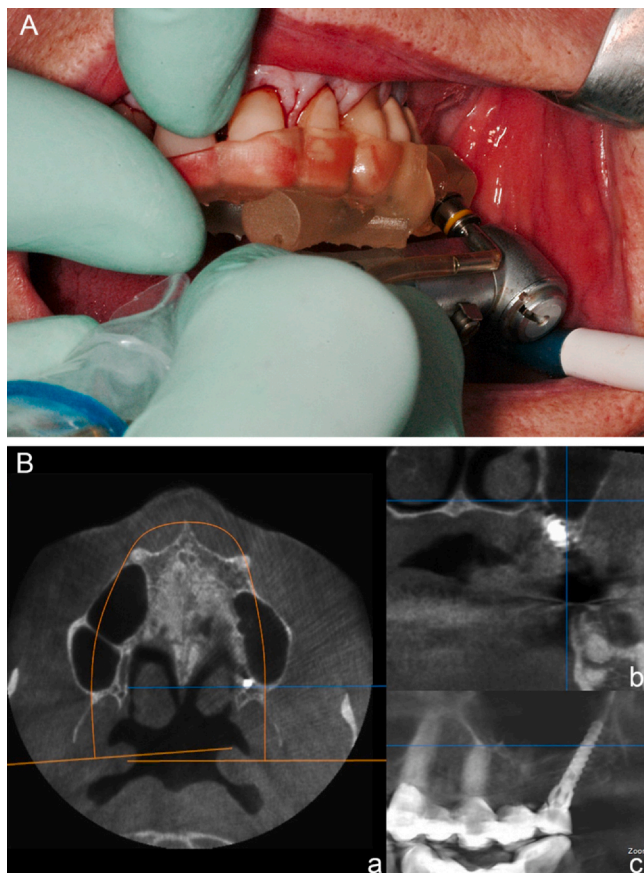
A, Preparation of pterygoid implant bed in left posterior maxilla using acrylic resin CAD-CAM surgical guide with metal sleeve for improved implant placement precision. B, Postoperative CBCT image composed of axial (a), coronal (b), and sagittal sections (c). Sections show 3D position of tubero pterygoid implant. CAD-CAM, computer-aided design and computer-aided manufacturing; CBCT, cone beam computed tomography.
